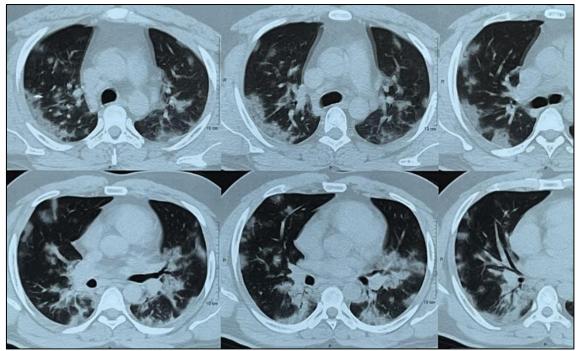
HRCT thorax showing peripheral, axonal at some points, pleural based opacity with GGO and consolidation with line of demarcation between normal and abnormal lung in bilateral upper and lower lobes
